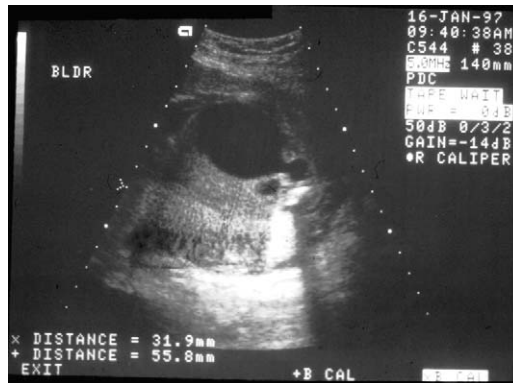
Ultrasound image of bladder outlet obstruction with enlarged bladder, classic keyhole appearance seen with posterior urethral valves, and anhydramnios.
